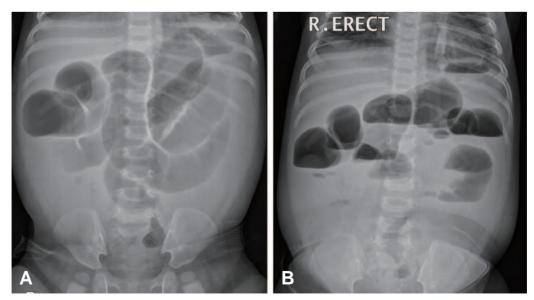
Simple abdominal radiography showed multiple dilated loops of the small bowel, with air-fluid level. (A) Simple abdomen supine view. (B) Simple abdomen erect view.
